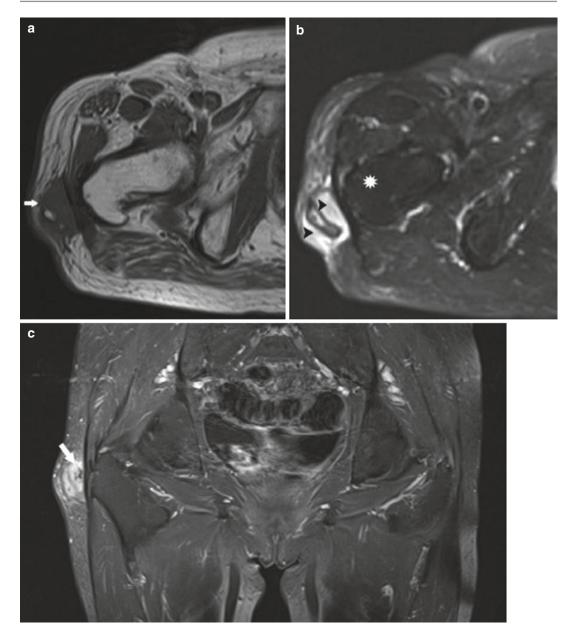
Ischemic fasciitis, also called decubital fasciitis. A 77-year-old immobilized woman presenting with a hard, palpable, and fixed mass over the greater trochanter. MR imaging revealed a subcutaneous mass lesion abutting the iliotibial band. (a) On T1-weighted images (WI), the lesion was isointense to the muscle (*white arrow*), with a central focus of high signal intensity. (b) Fat-suppressed (FS) T2-WI showed predominantly hyperintense signal (*black arrowheads*) with intralesional foci of low SI, adjacent to the right greater trochanter (*white*
